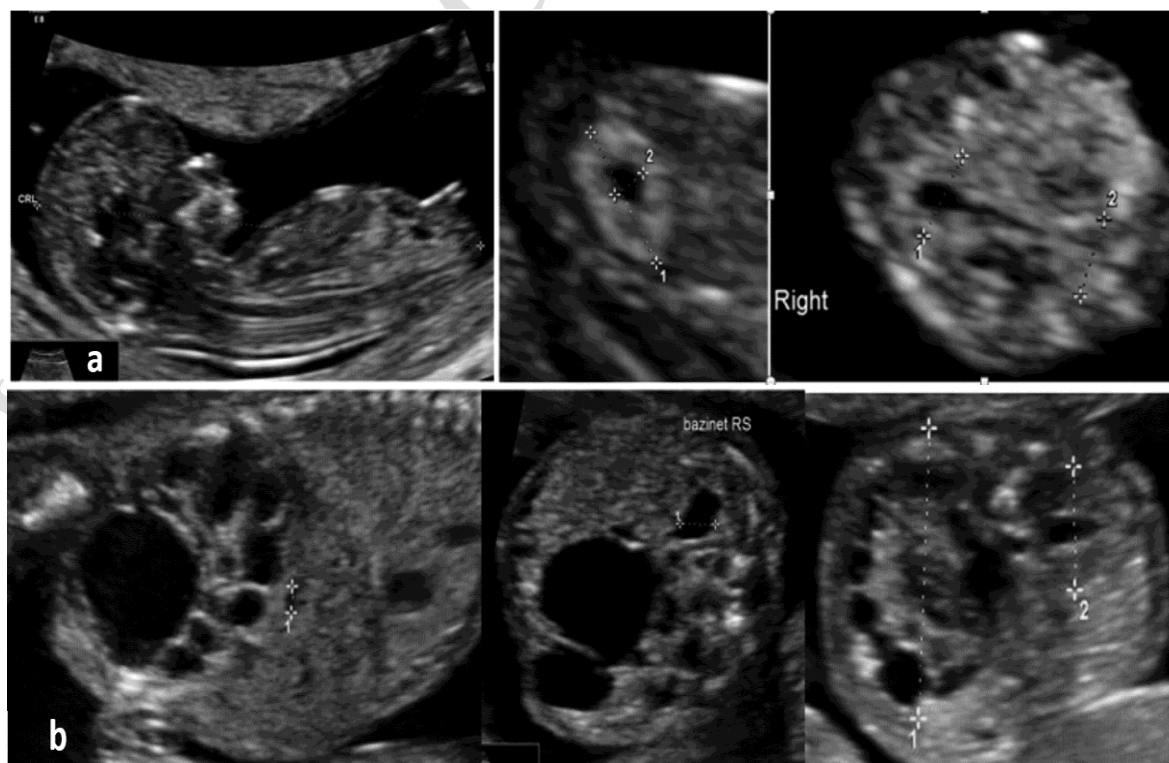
Case 1, ultrasound features 11+3 gestational weeks (a) and 16+2 gestational weeks (b)
